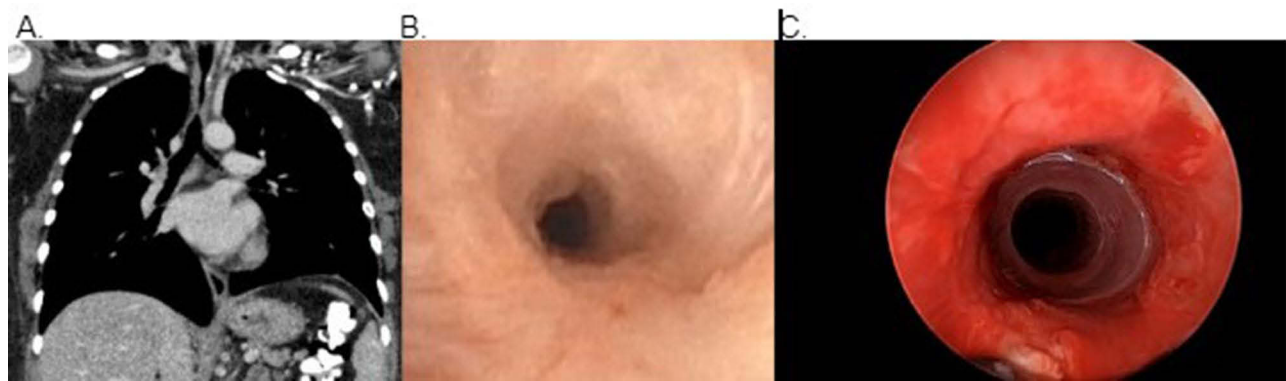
Grade 3, complex, concentric stenosis seen on CT chest (A) and pre-dilation bronchoscopy (B). Post-procedure bronchoscopy reveals airway patency with silicone studded hourglass stent in place (C).
